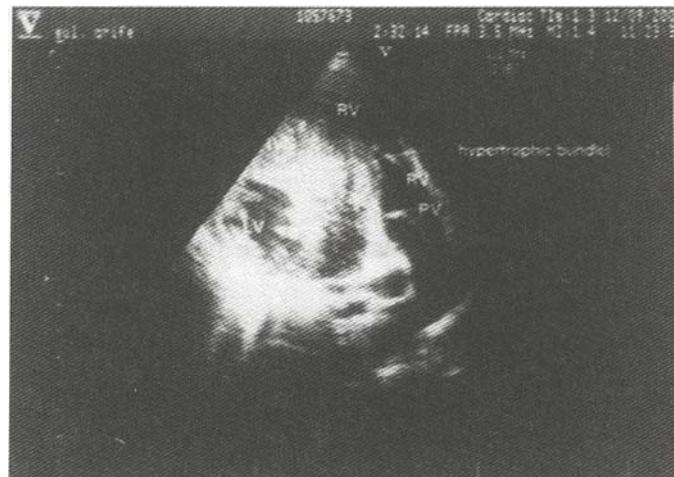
Echocardiographic pre-operative view of the double-chambered right ventricle (RV: right ventricle, IVS: interventricular septum, LV: left ventricle, PV: pulmonary valve).
